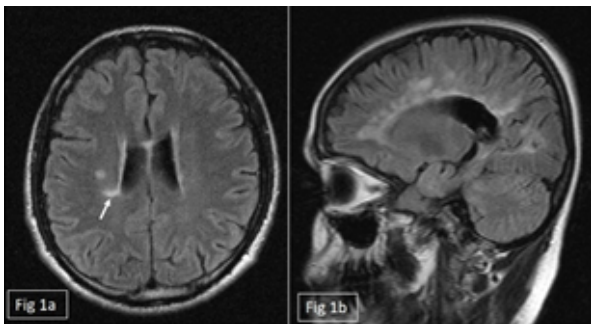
Axial and Sag FLAIR image showing ovoid hyperintense lesions perpendicular to the ventricles (arrow) giving Dawson fingers appearance.
